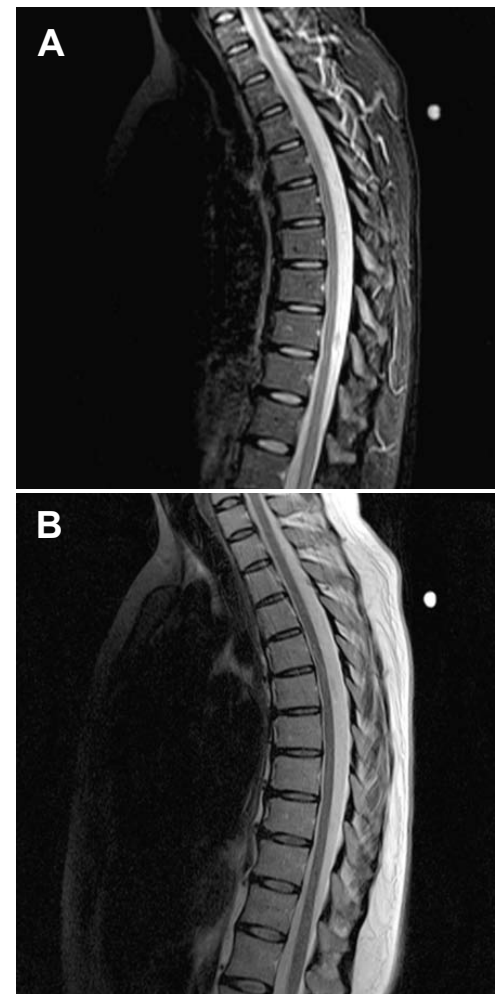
MRI of the spine. (A) Sagittal STIR. (B) Sagittal T2W. Courtesy of University of Iowa Carver College of Medicine.
